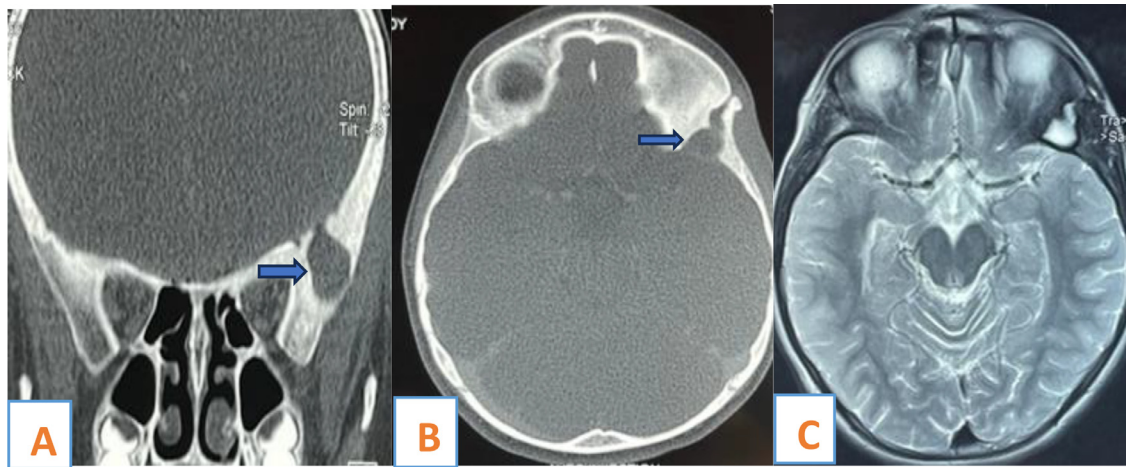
CT brain bone window coronal (A) and axial (B) sections of intradiploid dermoid cyst fistulizing at the skin (blue arrow). MRI well-circumscribed extracranial tumor component (C).
